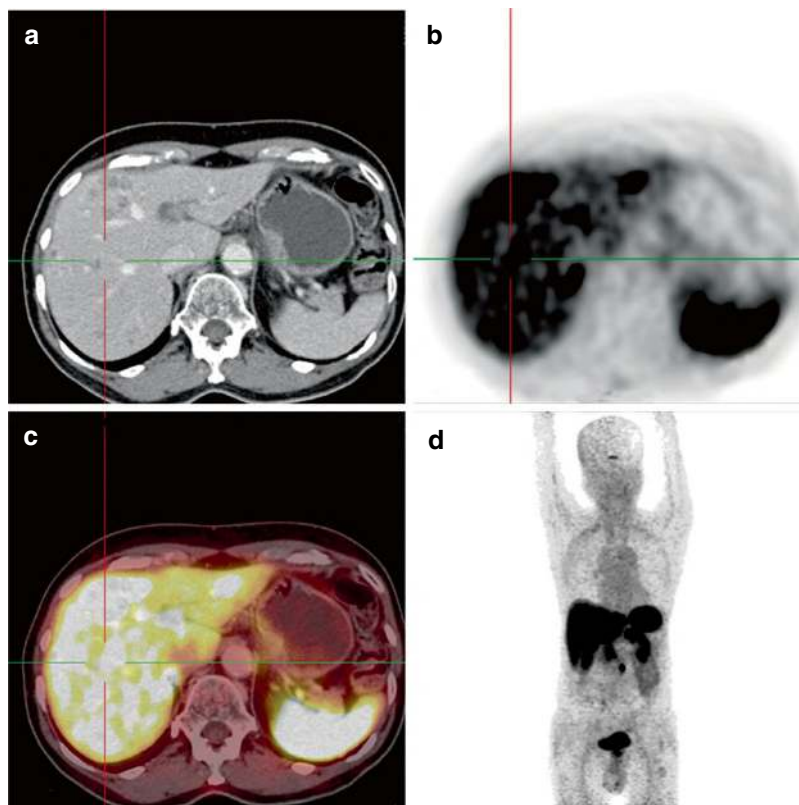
In the setting of the fever of unknown origin, CT image showing multiple hypodensities in image a noted with the diffuse uptake in the entire liver parenchyma in the images b, c, and d consistent with hepatitis
